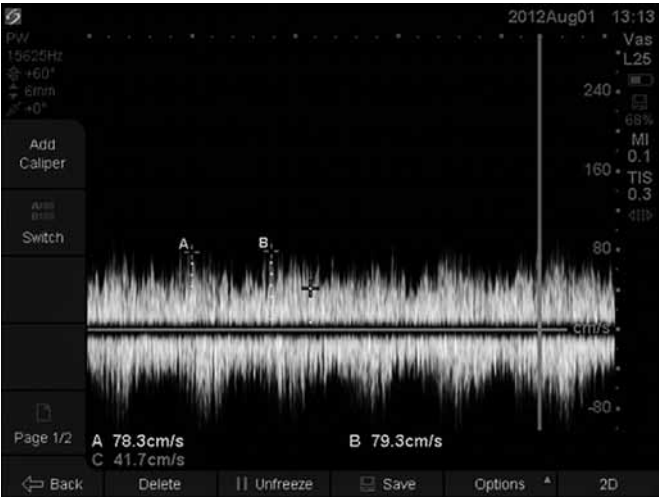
Ultrasound image for a mean velocity Doppler measurement at 2 cm from the needle tip at 200 mL/min blood flow (Qb).
